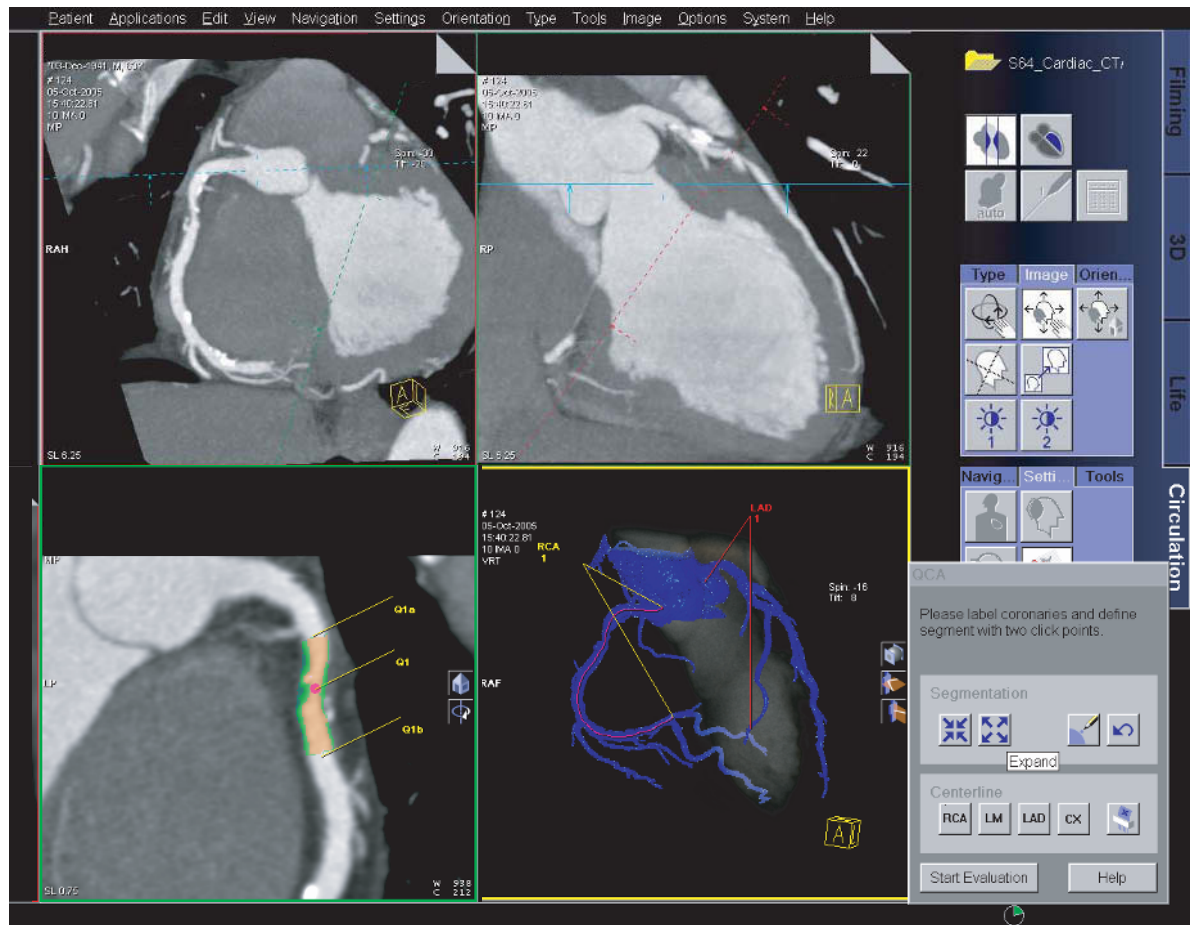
Coronary CT angiography examination obtained with a 64-slice CT scanner with 0.6-mm collimation and 0.33-s rotation time. Automated segmentation of the coronary arteries and display with MIP reveals several lesions in the proximal left and right coronary arteries. With the resolution provided by 64-slice CT, plaque analysis becomes feasible using advanced segmentation tools. (Case study courtesy of University of Erlangen, Germany)
